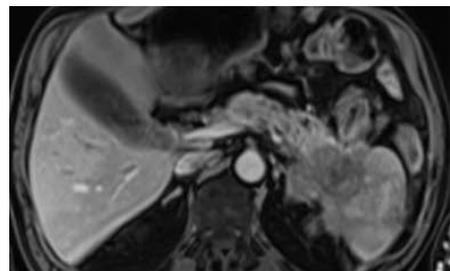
CE MRI of upper abdomen; Axial plane; Pancreas tail and body massive neoplasm with local infiltration, and infiltration of spleen.
